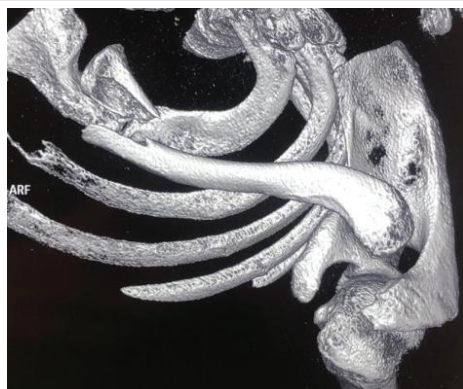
The CT scan showed a unacceptable reduction of lateral dislocation and medial fracture.
